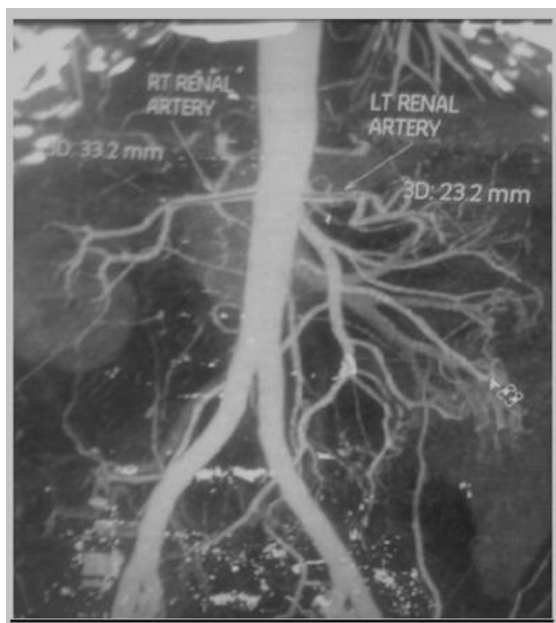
CTA scan showing bilateral extra renal branching. The left is at 2 cm and the right at 3 cm from abdominal aorta. Branching at 2 cm or less is considered as early extra renal branching.
